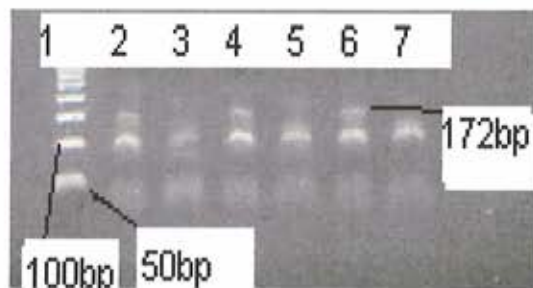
NQO1* RFLP gel: Lane 1 Ladder 50bp, Lane (2, 4, 5, 6) have (CT) genotype, Lane (3) (TT) genotype.
